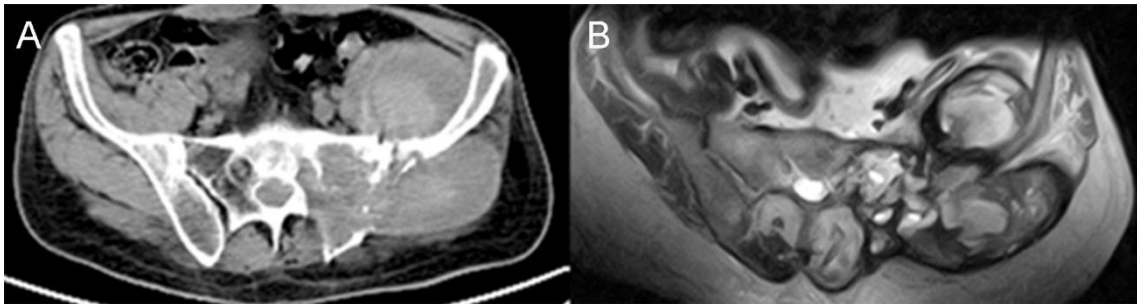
Sacral osteosarcoma: A. axial CT image, B. axial MRI image*
